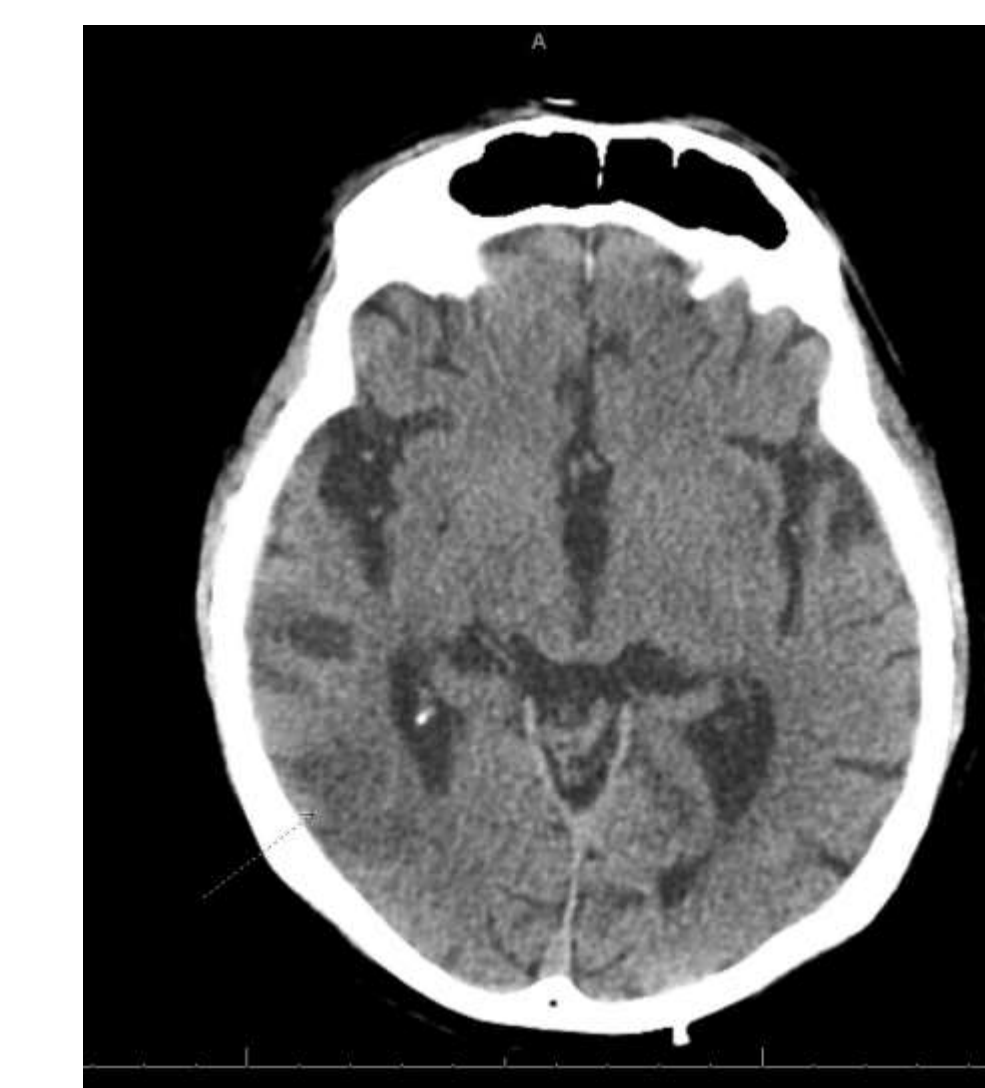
Computed Tomographic image of right inferior parietal lobe infarct
